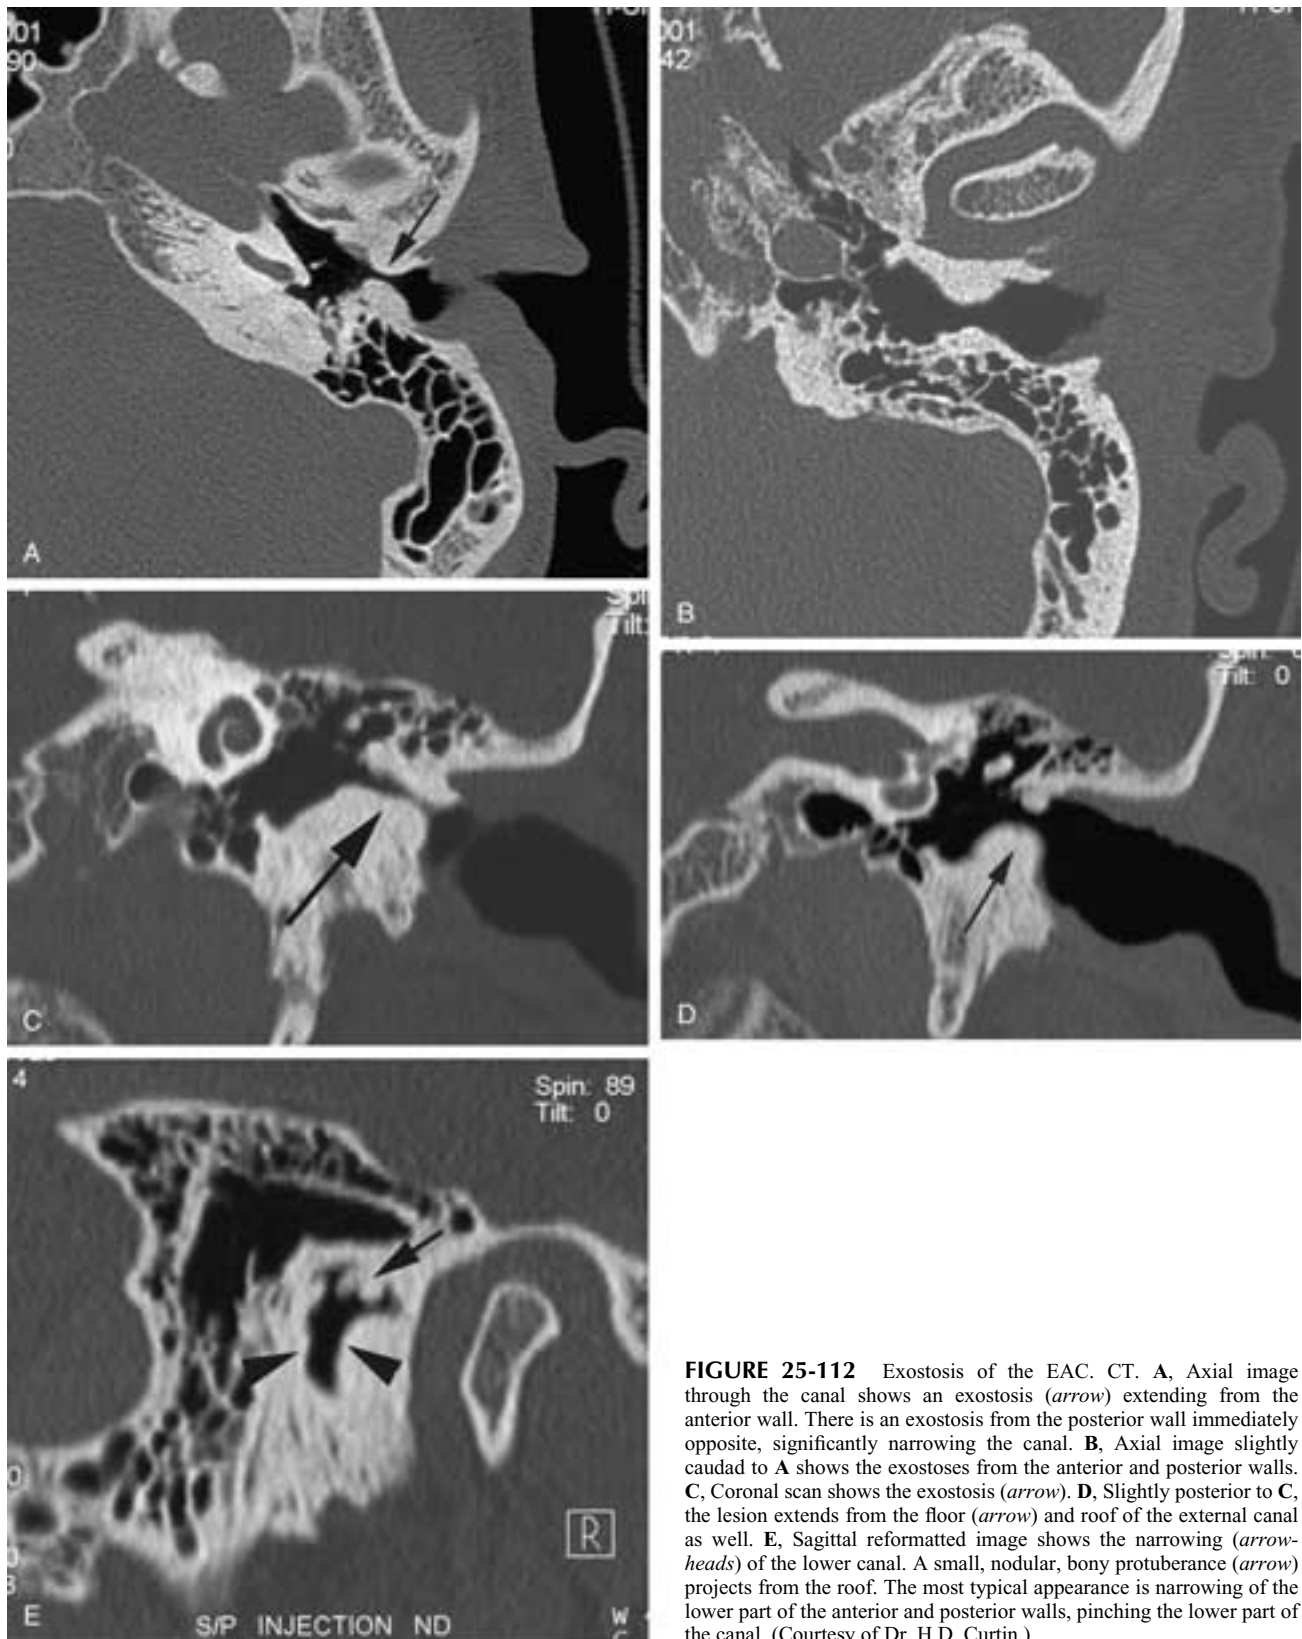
Exostosis of the EAC. CT. A, Axial image through the canal shows an exostosis (*arrow*) extending from the anterior wall. There is an exostosis from the posterior wall immediately opposite, significantly narrowing the canal. B, Axial image slightly caudal to A shows the exostoses from the anterior and posterior walls. C, Coronal scan shows the exostosis (*arrow*). D, Slightly posterior to C, the lesion extends from the floor (*arrow*) and roof of the external canal as well. E, Sagittal reformatted image shows the narrowing (*arrow-heads*) of the lower canal. A small, nodular, bony protuberance (*arrow*) projects from the roof. The most typical appearance is narrowing of the lower part of the anterior and posterior walls, pinching the lower part of the canal. (Courtesy of Dr. H.D. Curtin.)
